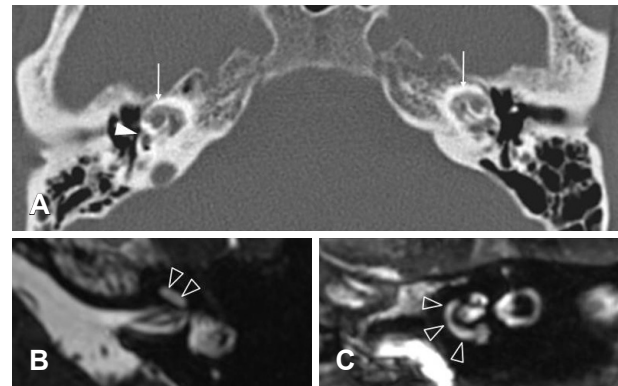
Radiologic findings of the temporal bone. Axial images of temporal bone CT demonstrated double ring effect of the cochlea (white arrows) and hypodensity at fissula ante fenestram (white arrowhead) on both sides (A). On MRI, patency of the cochlear basal turn of the left side was identified on axial (empty arrowheads in B) and parasagittal (empty arrowheads in C) views (B and C).
